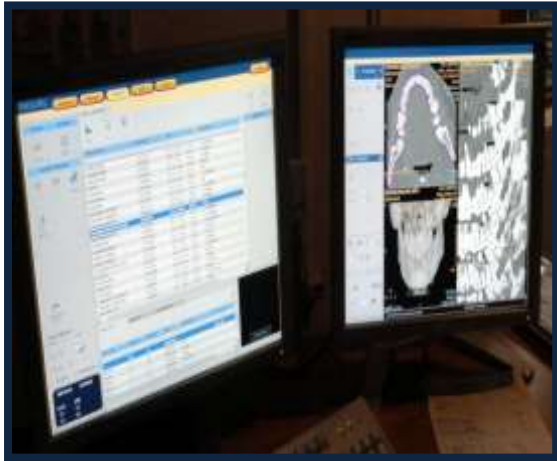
Post-processing CT workstation.
